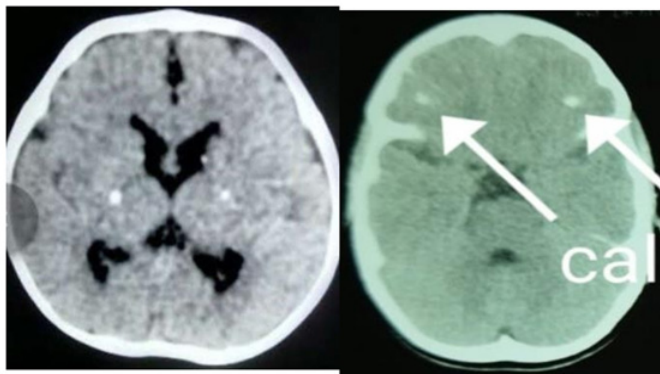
Case - CT scan pictures showing periventricular – intracranial calcification.
